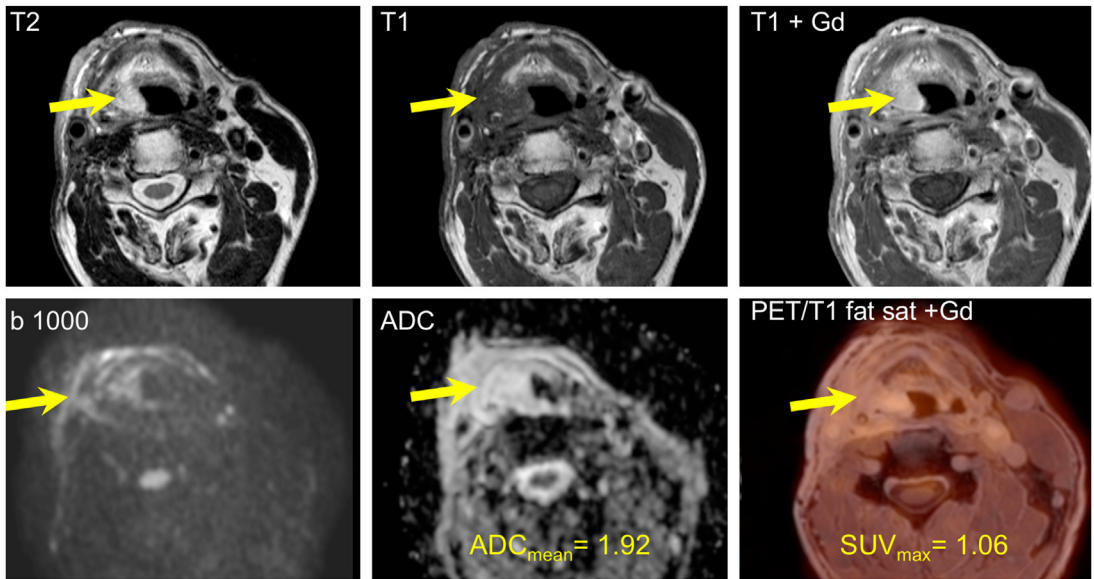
Posttreatment inflammatory edema in a patient with radiochemotherapy and neck dissection for an SCC of the oral cavity. Note a poorly delineated area with high signal intensity on T2, major contrast enhancement, no restriction of diffusion and no relevant FDG uptake (yellow arrows).
